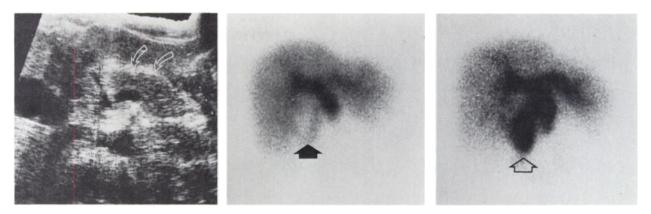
Case 3. Sonogram (left): pancreas appears enlarged and somewhat lucent, indicating pancreatitis (arrows). Tc-HIDA scintigram at 1 hr (center): photon-deficient gallbladder (arrow) is identified. Common bile duct and intrahepatic ducts appear prominent. No evidence of bowel excretion. Tc-HIDA scintigram at 4 hr (right): complete gallbladder filling (open arrow) is noted. Bile ducts are prominent without evidence of bowel activity.
